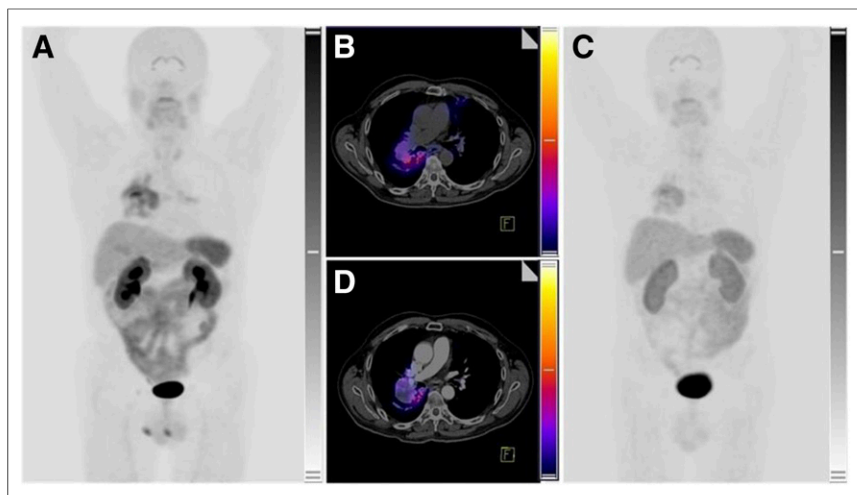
A 62-y-old man with lung adenocarcinoma. (A and B) ^{68}Ga -DOTA-E-[c(RGDfk)] $_2$ PET/CT before treatment with multikinase inhibitors shows intense avidity for radiotracer in right lung lesion and in ipsilateral and contralateral mediastinal lymph nodes. Tumor volume is 178 cm 3 , with SUV $_{\text{max}}$ of 7.6. (C and D) PET/CT posttherapy images show significant reduction of avidity in lung lesion and lymph nodes, with tumor volume of 56 cm 3 and SUV $_{\text{max}}$ of 3.5 (scale, 0–10 SUV-body weight). PFS of this patient was 6 mo.
